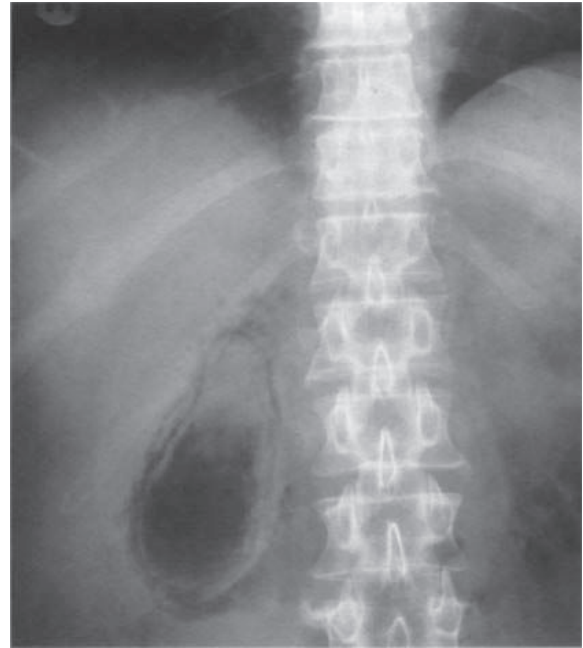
X-ray demonstrating gas in the gallbladder in emphysematous cholecystitis.
